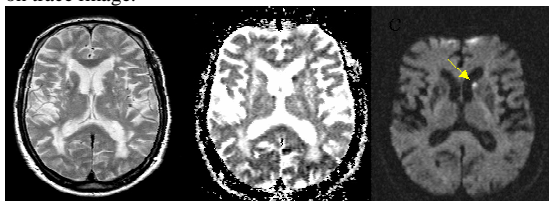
Example of a small ischemic acute lesion, that was the main target searched for in this study. T<sub>2</sub>-weighted image (a), ADC map (b), and trace DWI (c) in a patient with sudden onset abulia. Extensive chronic white matter and basal ganglia lesions are noted on the T<sub>2</sub>-weighted image. A small acute ischemic lesion in the head of the caudate is noted on the ADC map and DWI (yellow arrow) well explaining the acute syndrome.
